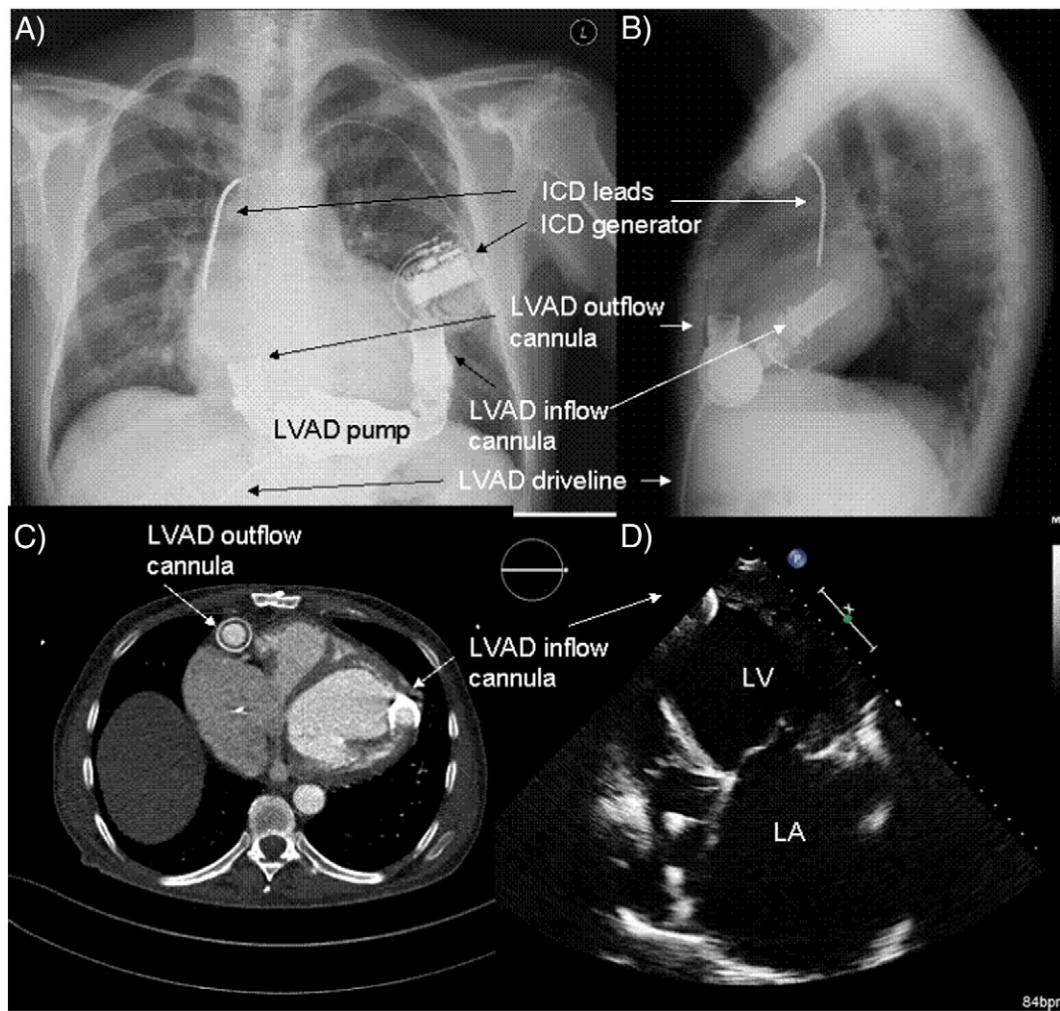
Heart-Mate II model of left ventricular assist device (LVAD) appearance in posterior–anterior (A) and lateral (B) chest X-ray, computerized tomography (C) and ultrasound examination (D). ICD = implantable cardioverter–defibrillator; LV = left ventricle; LA = left atrium.
